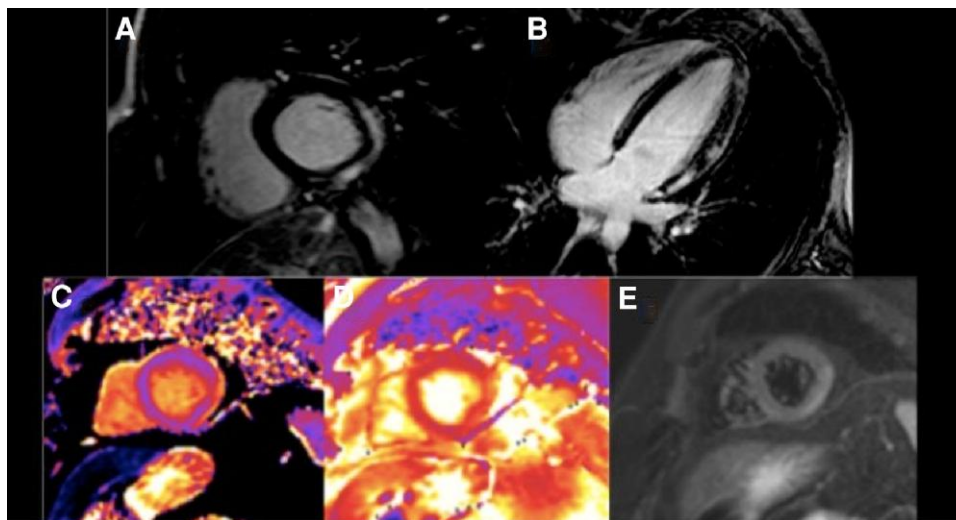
Cardiovascular magnetic resonance images in a 44-year-old woman with a metastatic breast cancer and immune checkpoint inhibitor-associated acute myocarditis, non-ischaemic subepicardial late gadolinium enhancement in the inferior and inferolateral walls: (A, B); concomitant myocardial oedema demonstrated by elevated native T1 (1280 ms) on T1 mapping (C); elevated T2 (72 ms) on T2 mapping (D); high signal intensity on T2 STIR (E).
